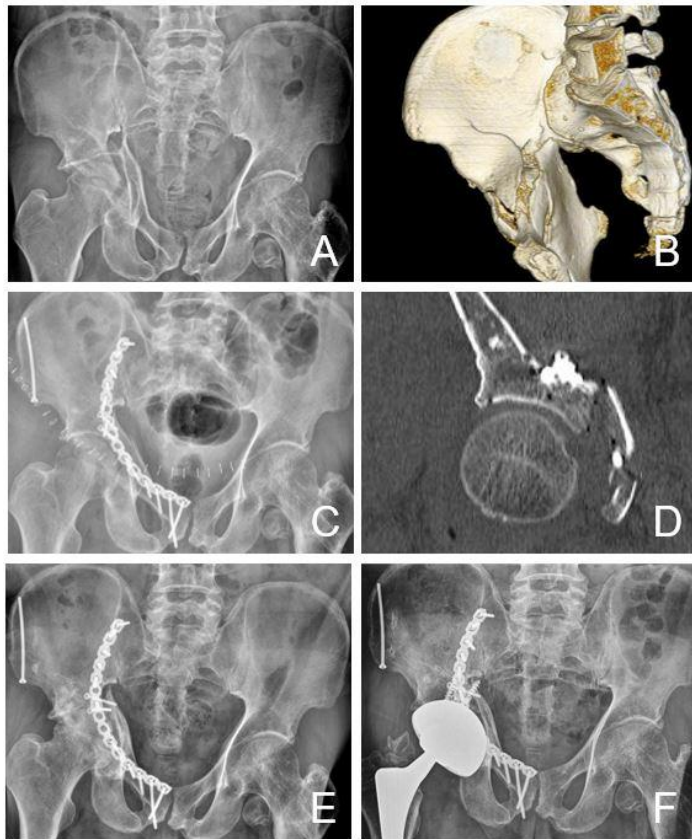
Case presentation III. A 57-year-old man underwent indirect fixation with suprapectineal plate. (A) Radiograph shows both column fracture with 20 mm displacement. (B) Three-Dimensional CT scan shows both column fracture with quadrilateral plate displacement. (C) Indirect fixation with suprapectineal plate is done. (D) CT scan shows congruent reduction. (E) Radiograph obtained 15 months after surgery shows poor grade with Matta's outcome grading with joint space narrowing above 50% and severe subchondral sclerosis (F) Radiograph obtained after conversion total hip arthroplasty 15 months after initial surgery. CT: computed tomography
